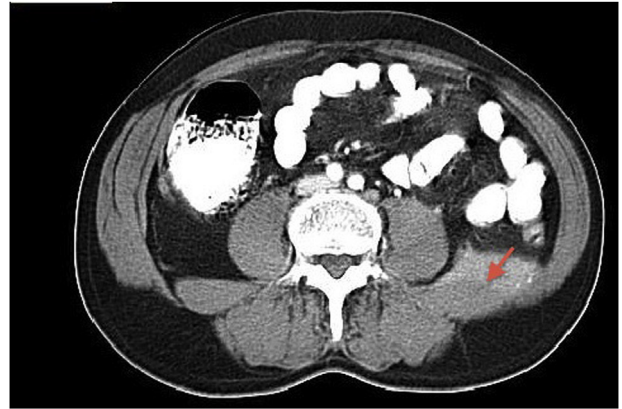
Patient Pelvic CT with mass.
